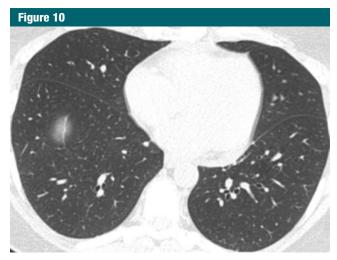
Normal bronchial walls. CT scan in asymptomatic nonsmoker with normal spirometric findings demonstrates normal airways.
